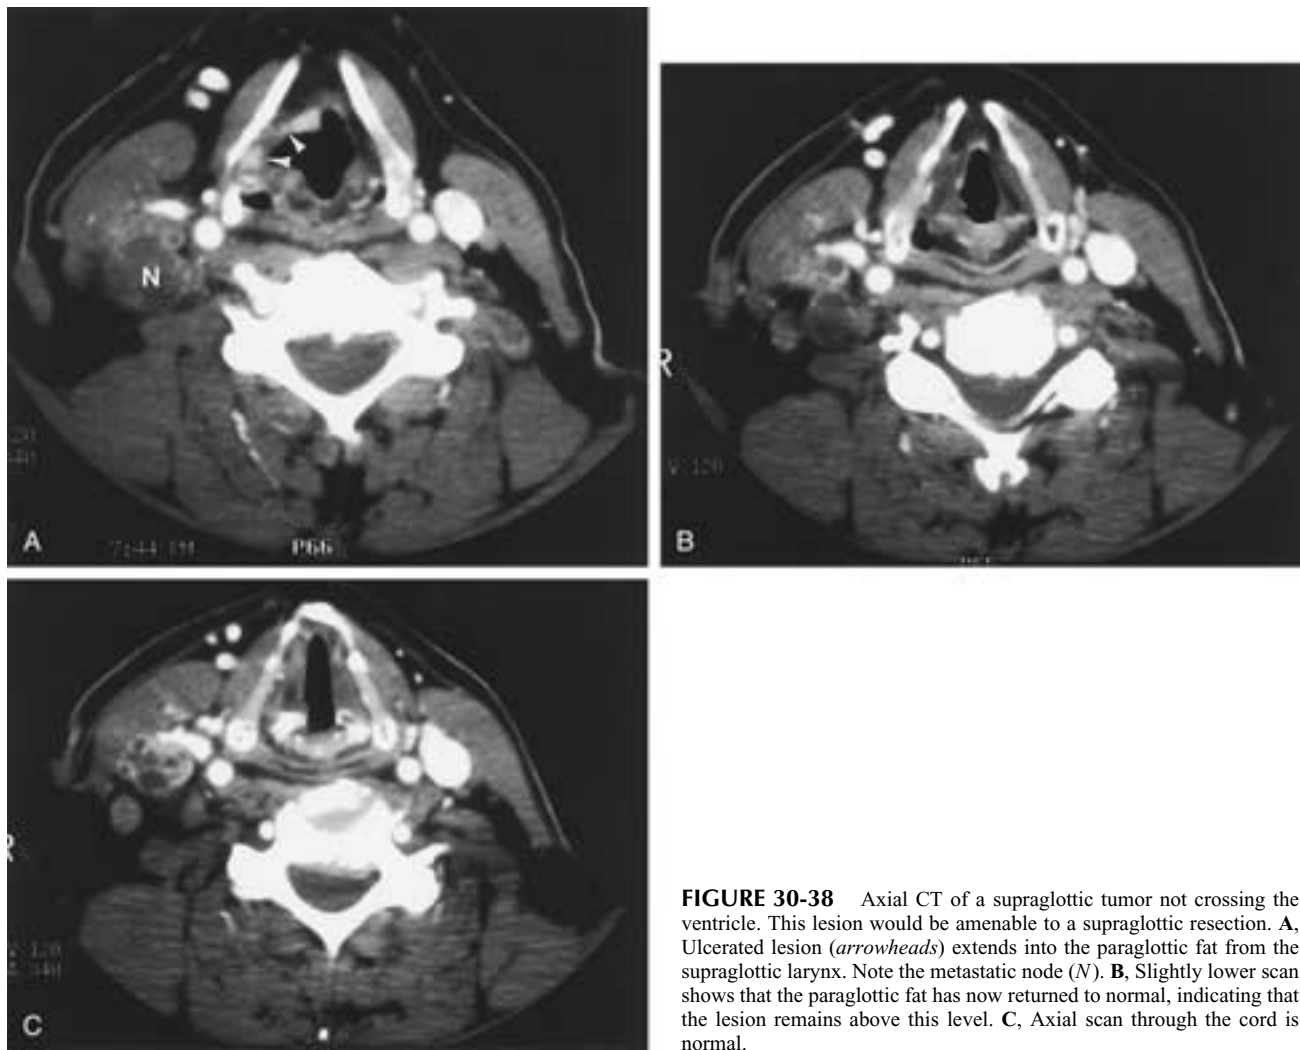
Axial CT of a supraglottic tumor not crossing the ventricle. This lesion would be amenable to a supraglottic resection. A, Ulcerated lesion (*arrowheads*) extends into the paraglottic fat from the supraglottic larynx. Note the metastatic node (*N*). B, Slightly lower scan shows that the paraglottic fat has now returned to normal, indicating that the lesion remains above this level. C, Axial scan through the cord is normal.
